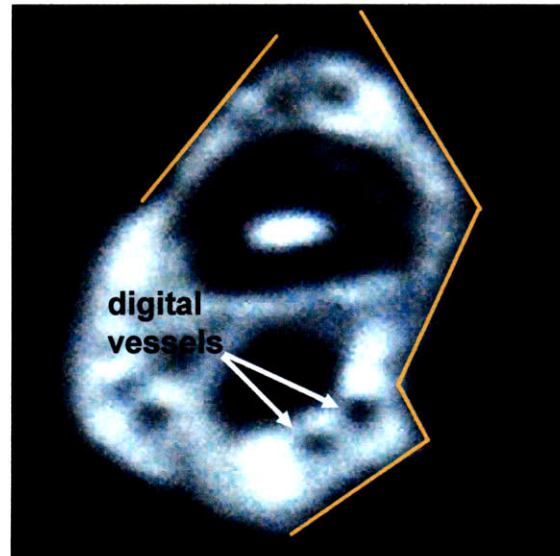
T1-weighted MRI of finger base deformed by passively loaded ring sensor.
